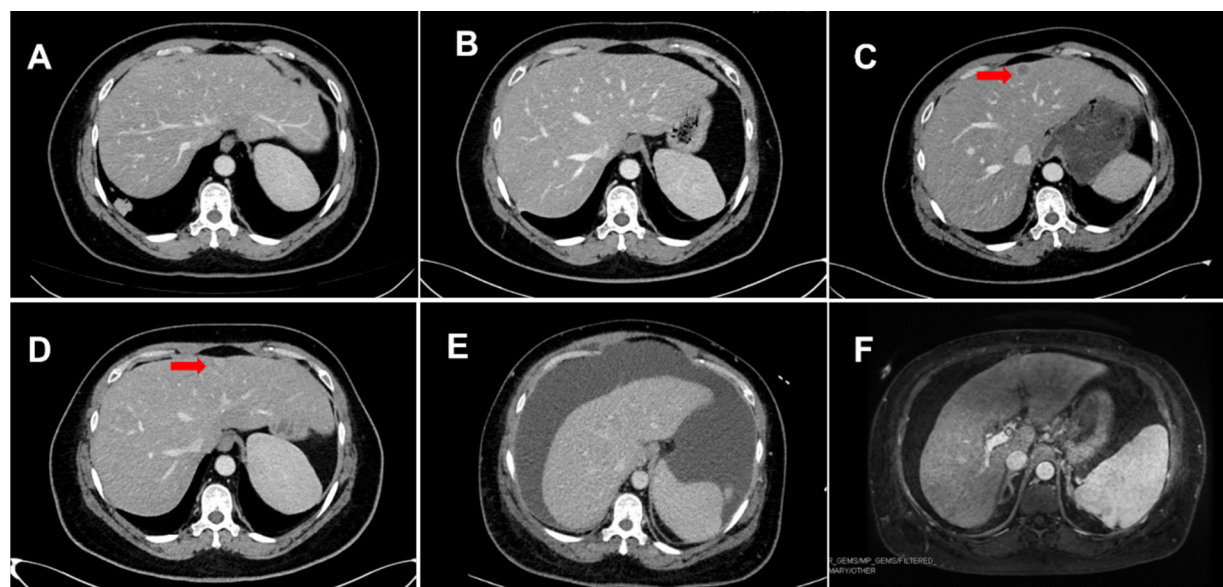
Computed tomography (CT) and magnetic resonance imaging (MRI) scan of the liver during treatment. A, Before treatment, July 2019. B, After 2 cycles of pembrolizumab and chemotherapy, August 2019. C, Disease progression and liver metastases, April 2020. D, After 5 cycles of treatment with gemcitabine plus cisplatin, October 2020. E, The patient was admitted to our hospital again in March 2021. F, After TIPS, May 2021.
